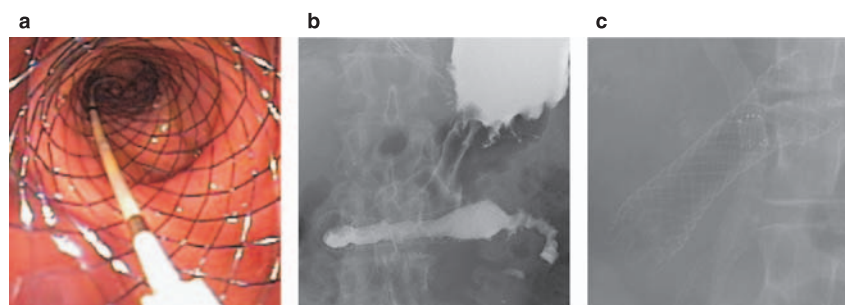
Placement of WallFlex duodenal stent. (a) Endoscopic and (b, c) radiographic views of WallFlex duodenal stent *in situ*.
